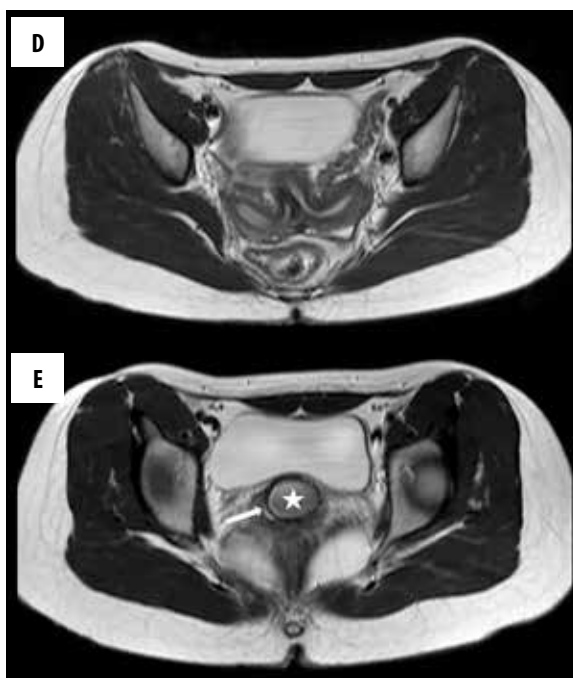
A 15-year-old girl with dysmenorrhea, case II. On a sagittal view, the right kidney (A) was absent and the left kidney (B) was hypertrophic. Axial sonography image (C) demonstrates dilated left hemivagina with echogenic content (arrowhead) and normal right hemivagina (arrow). Axial T2W images at the level of uterus (D) and vaginas (E) show uterus didelphys and dilated left hemivagina with slightly hypointense fluid consistent with haematocolpos (star) and normal right hemivagina (arrow).
